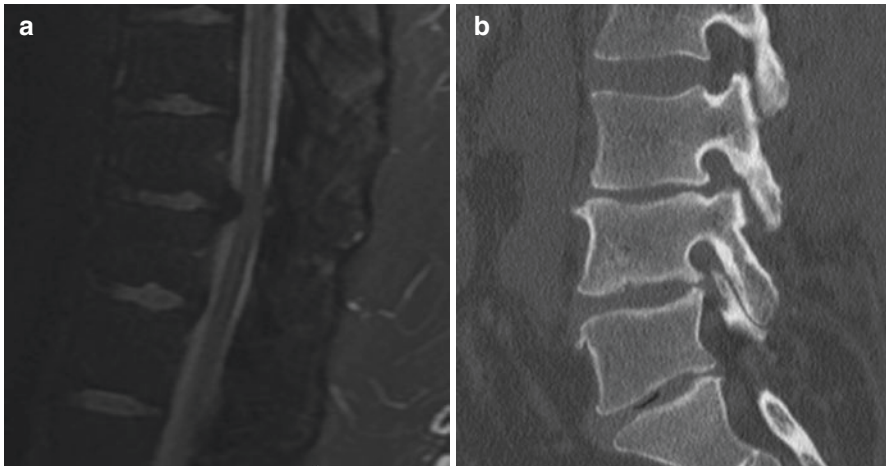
(a) A 29-year-old male with stenosis at L4–5 and L5–S1 from large herniated discs documented to present for over a year. New onset of paraparesis. Lumbar decompression considered but workup showed the real problem was the ruptured disc at T10–11. (b) A 50-year-old male with two failed right L3–4 decompressions. Had chronic LBP as well and right anterior thigh pain. Under a lot of stress. We spend almost a year on prehab addressing sleep, stress, and anger. Pre-op his back pain had decreased. This CT scan was 1 year prior to his third operation, which was a right L3–4 TLIF/ posterolateral fusion
